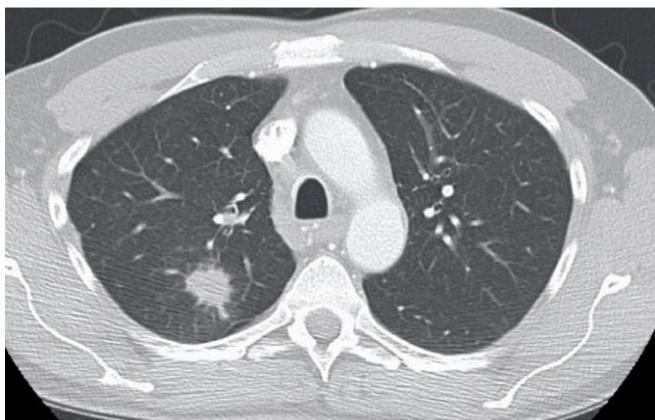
A computed tomography scan demonstrating tumour in the right upper lobe with irregular and sharp edges. Image: Tómas Guðbjartsson, Landspítali University Hospital.
